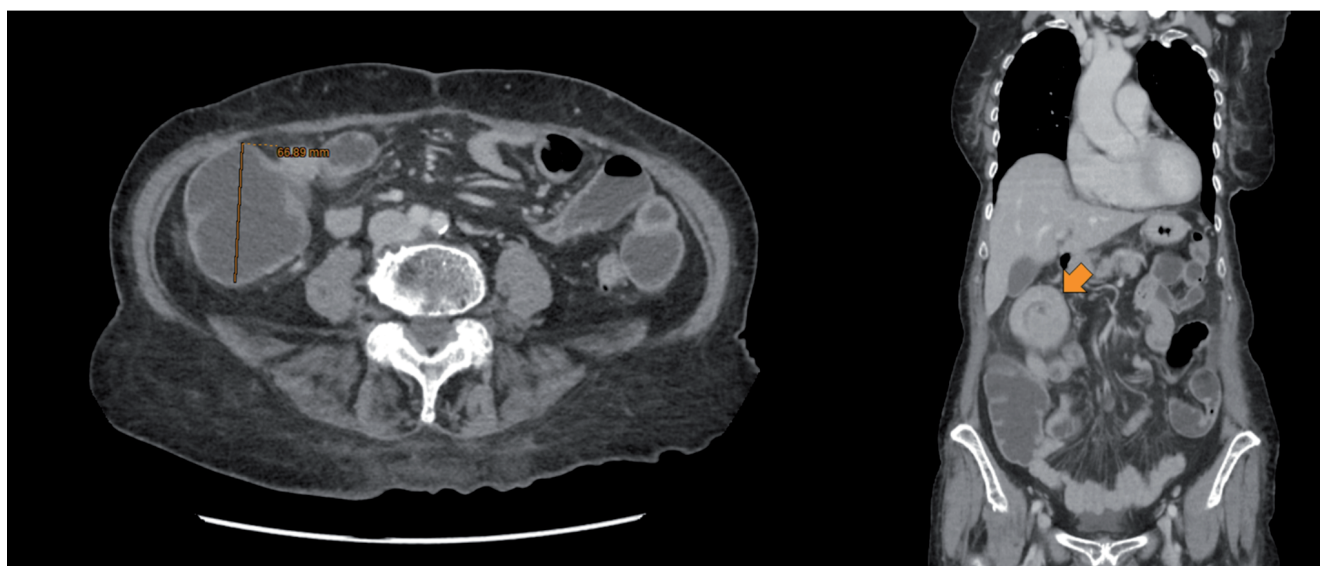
CT scan of the cecal dilation and the colonic mass located at the hepatic flexure with initial intussusception.
